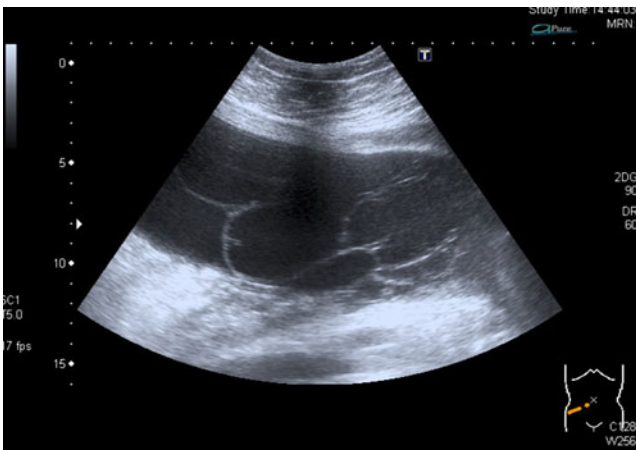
Abdominal ultrasound with Dopplers at initial presentation.
